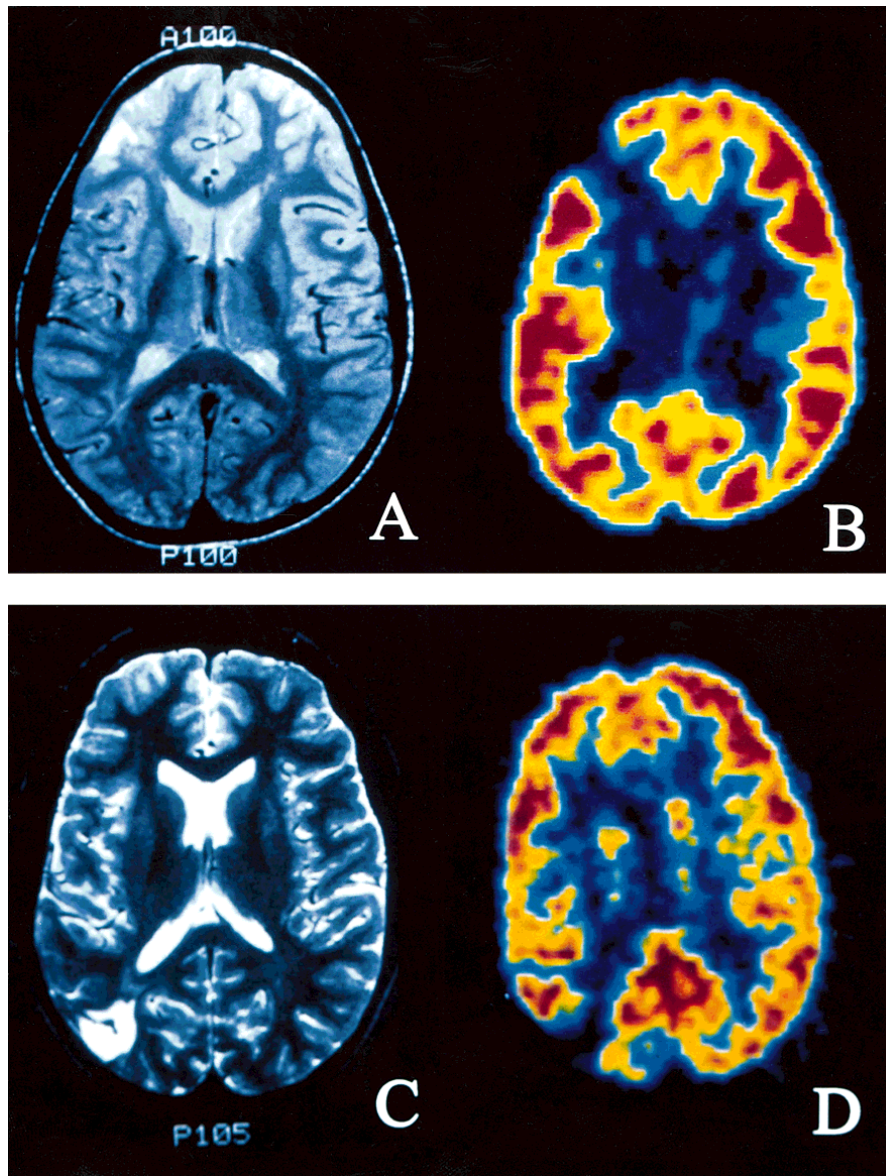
Comparison of PET and MRI images for two subjects. (A) MRI shows deep white matter infarcts and infarctive lesion of the right frontal cortex. (B) PET shows a focal reduction in glucose metabolism occurring in the cerebral cortex of the right frontal lobe. (C) MRI demonstrates cystic encephalomalacia in the right parietal-occipital area in the distribution of a distal branch of the middle cerebral artery. Similar abnormalities are present in the left frontal region. These correspond to locations of previous hemorrhage. Mild atrophy is present. (D) PET demonstrates a single, larger area of focal hypometabolism in the right temporo-occipital area. Metabolic activity in other cortical regions and in the cerebellum is normal.
